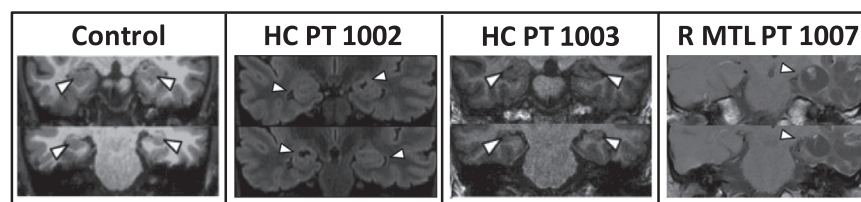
Coronal MRI scans for a healthy control, two patients with selective hippocampal damage bilaterally, and a patient with more extensive right MTL damage. Images for the control and patients 1003 and 1007 are T2 weighted, and for patient 1002 are fluid-attenuated inversion recovery (FLAIR).
